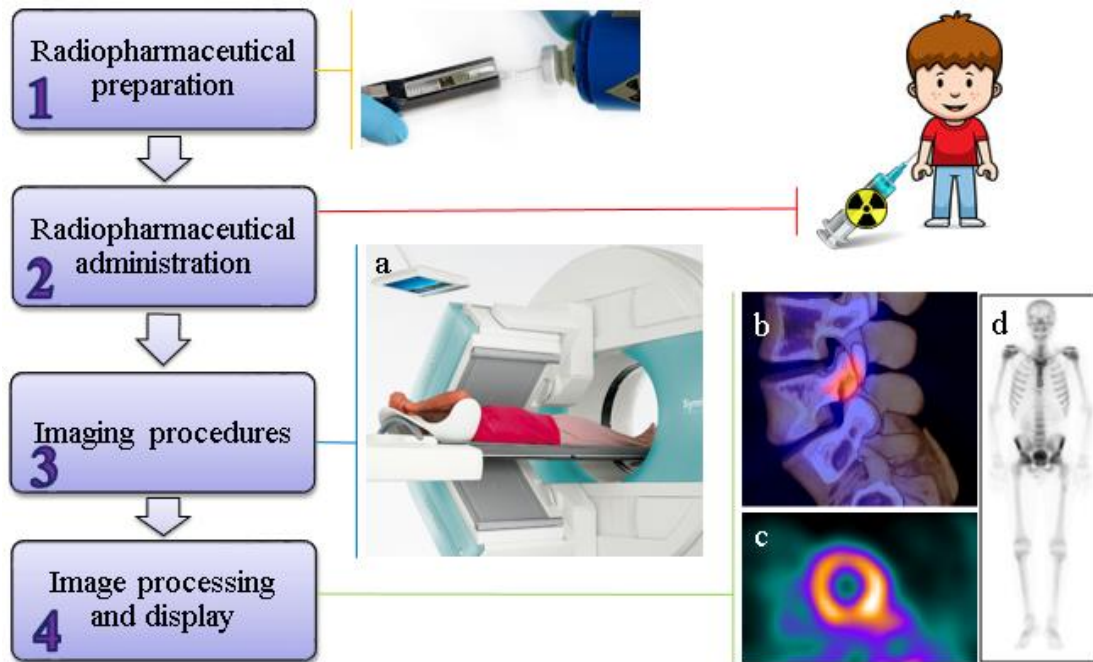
The typical processes of a nuclear medicine imaging procedure. (a) SPECT-CT imaging with patient lying on couch; (b) SPECT-CT image of lumbar spine with fracture; (c) myocardial perfusion image (Images taken from [3]); and (d) whole body bone scintigraphy (Image taken from [4])
